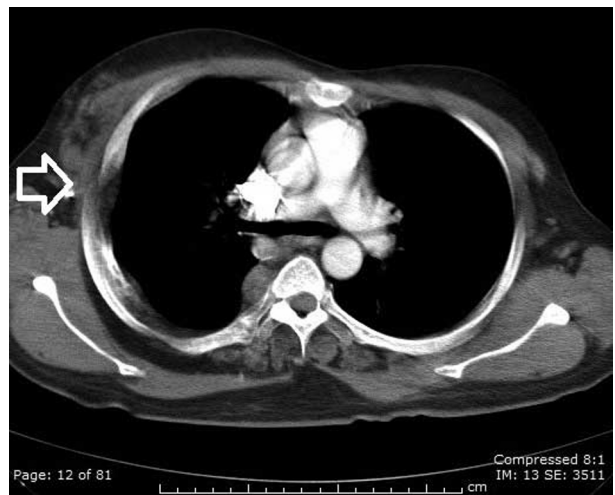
Proteus Syndrome in a 26-year-old male. Axial CT (All images were created with Siemens SOMATOM Sensation 64 Slice, mA 200, KVp 120). Note hemihypertrophy of the right chest, and a soft-tissue mass under the right crus (white open arrow).
